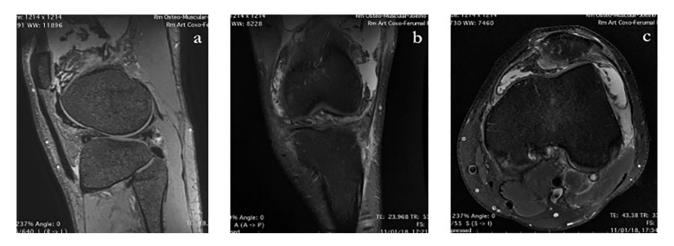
Sagittal (a), coronal (b), and axial (c) magnetic resonance imaging showing villous proliferation of the synovium with heterogeneous and hypointense areas.
